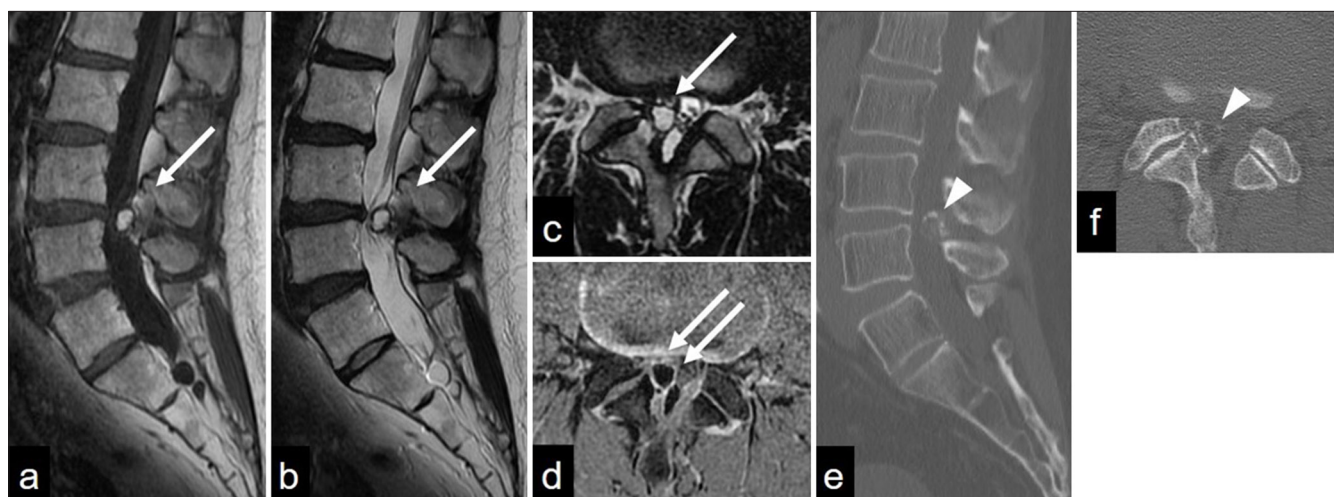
Lumbosacral (a) sagittal T1-weighted and (b) T2-weighted magnetic resonance imaging (MRI) and (c) an axial T2-weighted MRI showing the L3/L4 extradural mass (arrow); hyperintense and hypointense rim (T1- and T2-weighted MRI scans). (d) Hyperintensity in the lesion is not evident on the T1 fat-suppressed sequence (double arrows). (e) Sagittal and (f) axial computed tomography images showing an ossified nodular lesion attached to the right L3 inferior articular process (arrowhead).
